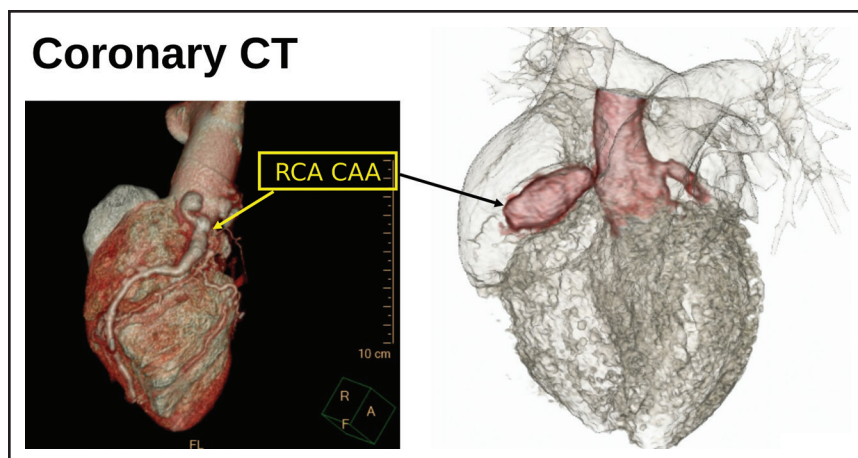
Three-dimensional reconstruction of coronary computed tomography angiography.
